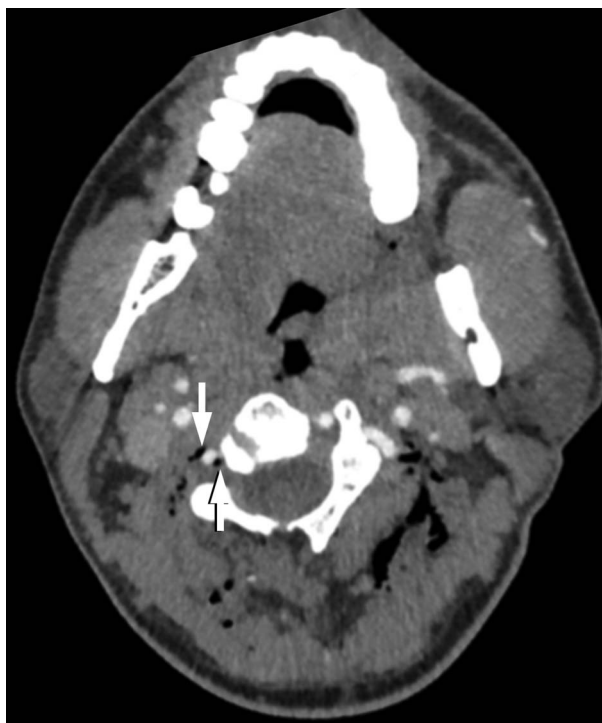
Axial computed tomographic angiogram demonstrates multiple foci of gas in the paravertebral soft tissue. There are 2 foci of gas (arrows) adjacent to the right vertebral artery.
